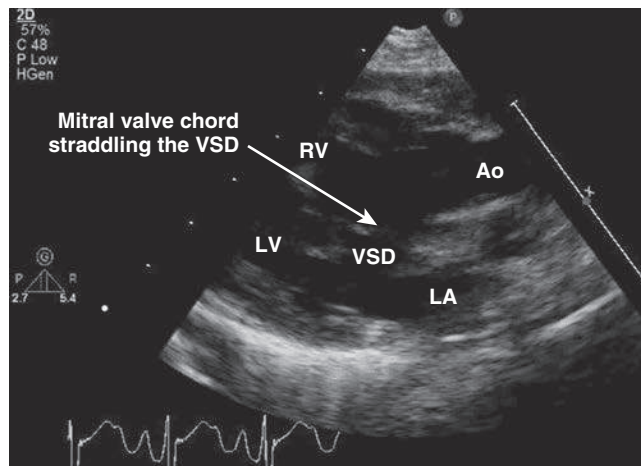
Echocardiogram in the parasternal long-axis view in double-outlet right ventricle. The arrow demonstrates a chord from the anterior leaflet of the mitral valve that straddles the VSD and is attached to the crest of the ventricular septum on the right ventricular aspect. Note the anteriorly placed Ao. Ao, Aorta; LA, left atrium; LV, left ventricle; RV, right ventricle; VSD, ventricular septal defect.
